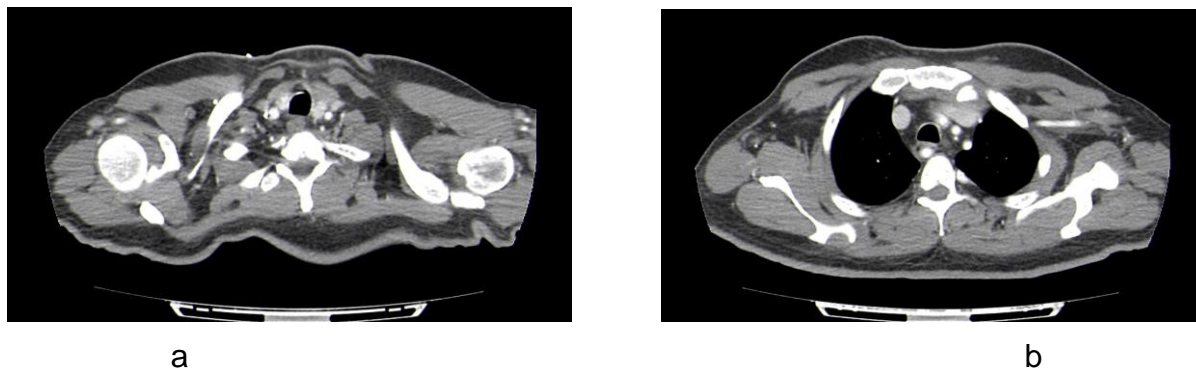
The CT SCAN demonstrated a massive pneumomediastinum. 2a: cross section; 2b coronal section, 2c sagittal section.
